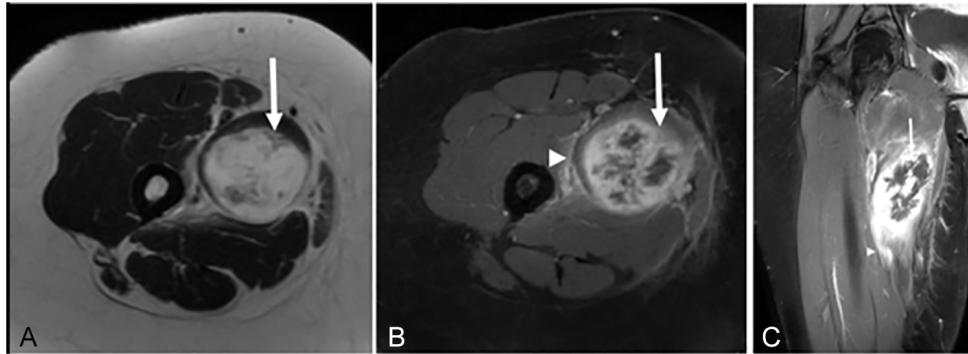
Female patient aged 23 years, after Covid-19 lockdown. She presented with pain at the right thigh, increasing during daily activities, after long-distance walking during lockdown. (A) An axial T2w MR image shows a predominately hyperintense mass (arrow) within the adductor longus muscle. (B) Heterogenous enhancement of the mass (arrow) and mild enhancement of the adjacent fasciae at the medial aspect of the thigh are seen on a fat-suppressed contrast-enhanced T1w MR image (arrowhead). (C) A coronal fat-suppressed contrast-enhanced T1w MR image shows a hypointense thick incomplete rim (arrow) and marked oedema of the surrounding muscle (arrowhead). The differential diagnosis included soft tissue sarcoma.
